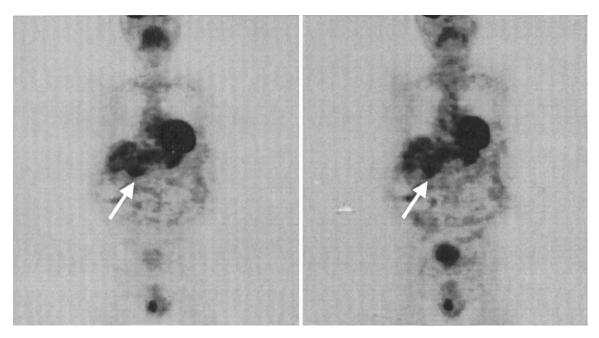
FDG PET showing a suspicious lesion at the liver hilum mimicking a Klatskin tumor (H.L.).
